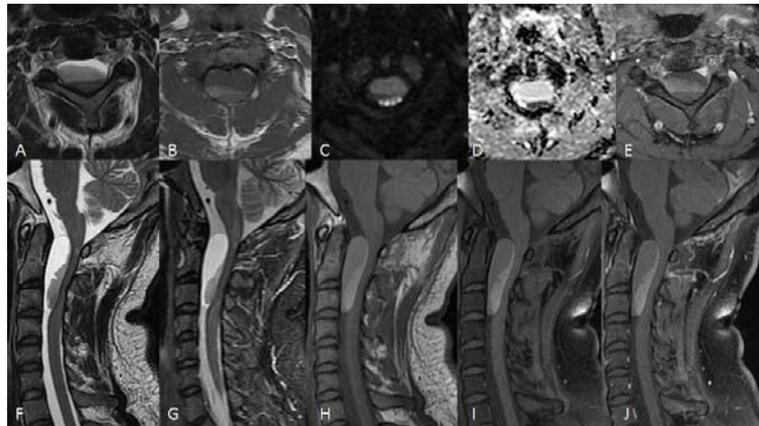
Case of cervical spinal neurenteric cyst: MRI Cervical spine. A-E: Axial T1WI, T2WI, DWI, ADC, Post-contrast Axial T1FS. F-J: Sagittal T2WI, STIR, T1WI, T1FS, Post-contrast T1FS. MRI revealed a well-defined extramedullary, intradural cystic lesion in the cervical spinal canal anterior to the spinal cord at the C2-C3 level, displacing and compressing the cervical cord posteriorly. The lesion showed dependent T1 hyperintense and T2 hypointense content, suggestive of an infranatant with increased protein-containing material. The extramedullary intradural lesion revealed no restricted diffusion or contrast enhancement.
